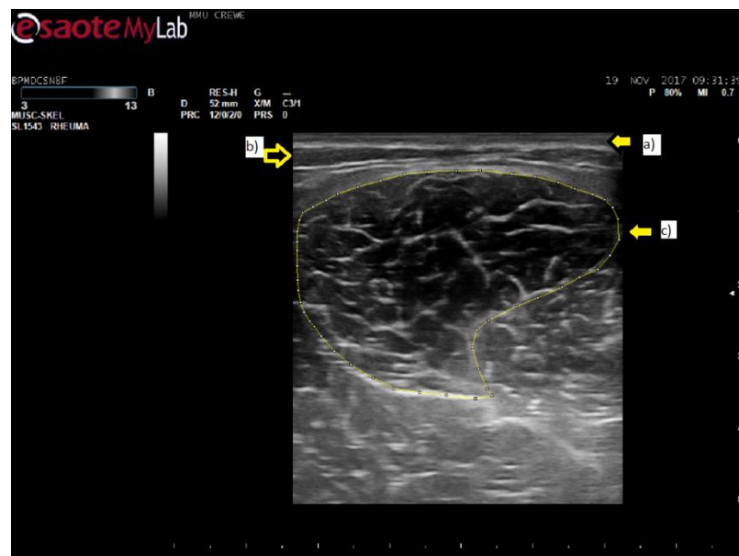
Semitendinosus Ultrasound Cross-sectional Area image. a) skin; b) subcutaneous fat; c) muscle aponeuroses. Note: image recorded during tests of the current thesis.
